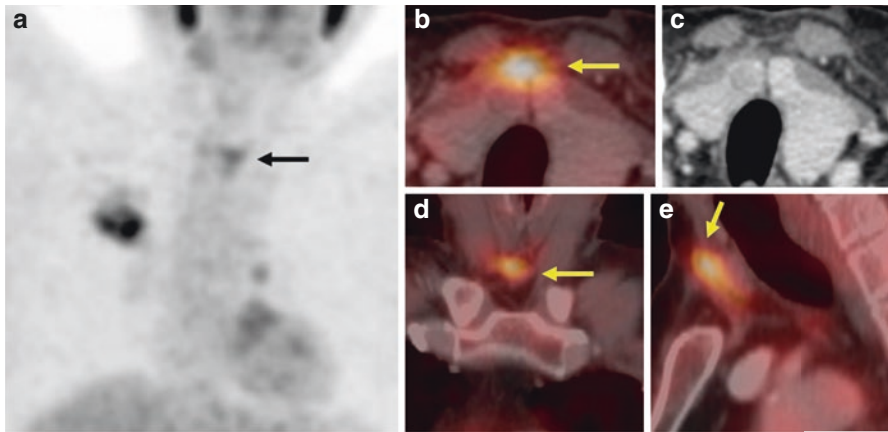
Whole-body PET/CT MIP (a), axial (b, c), coronal (d), and sagittal (e) images of a 49-year-old male with adenocarcinoma in the right lung. The patient had undergone mediastinoscopy 3 weeks prior to the PET scan for nodal assessment. Increased FDG uptake is noted in the suprasternal region at site of incision of the mediastinoscopy (arrow), due to inflammation
